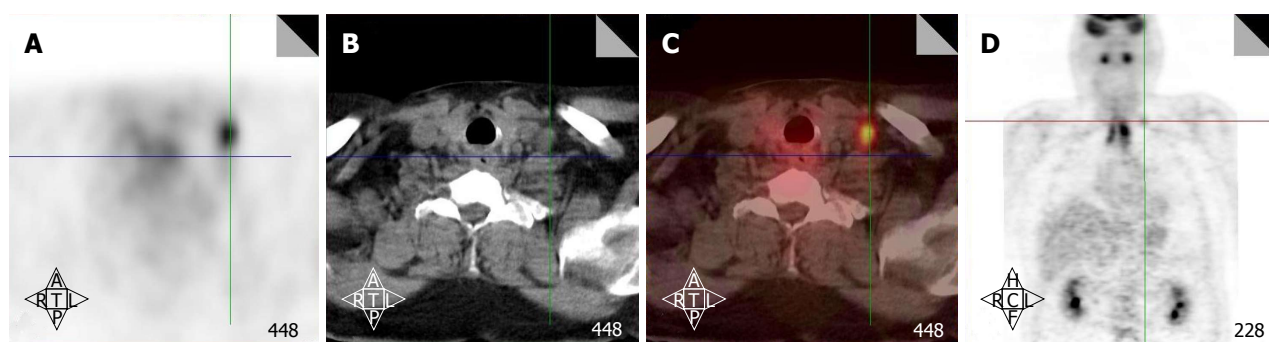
Positron emission tomography/computed tomography detects a low neck lymph node involved by metastasis. Increased FDG uptake in the low neck reveals a metastatic lymph node which would otherwise be difficult to detect because of the presence of muscular and vascular structures in this region of the neck (A-D). FDG: Fluorodeoxyglucose.
